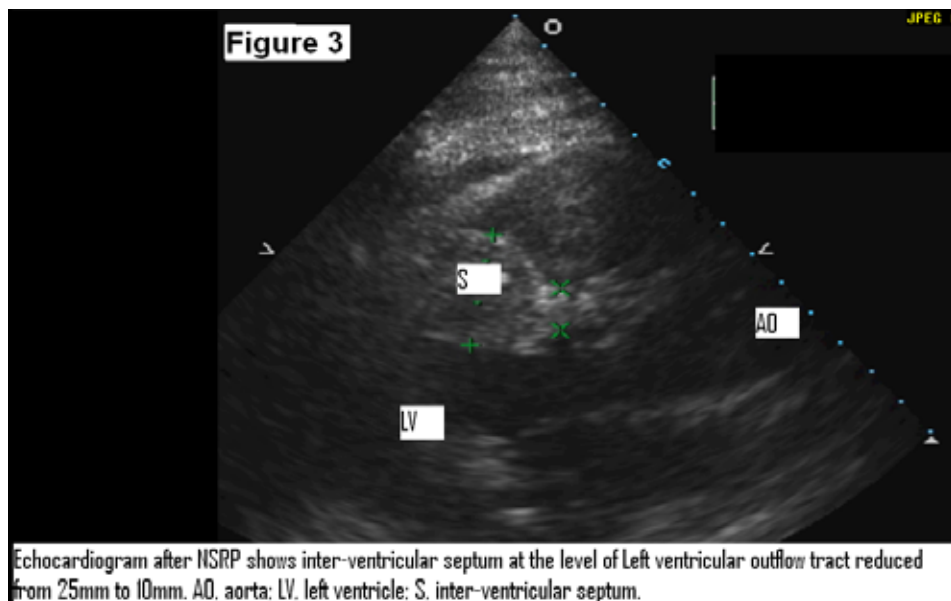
Echocardiogram after NSRP shows inter-ventricular septum at the level of left ventricular outflow tract reduced from 25mm to 10mm.
